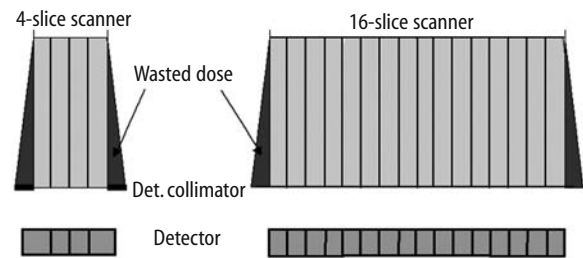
Dose profiles for a 4-slice CT system and a 16-slice CT system with equal collimated width of one detector slice. The relative contribution of the penumbra region, which represents wasted dose, decreases with increasing number of simultaneously acquired slices
